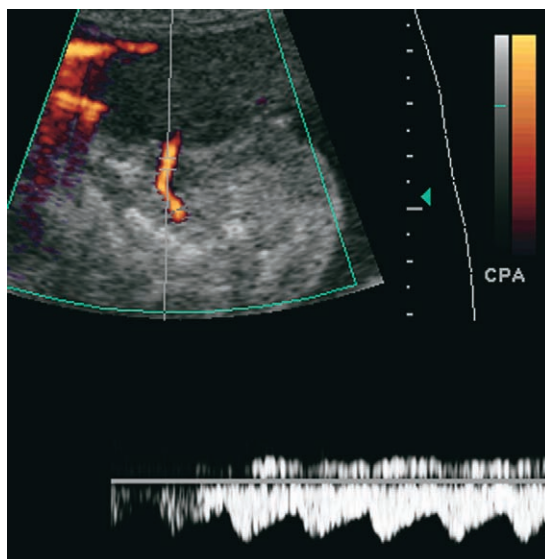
Color and pulse Doppler imaging of an acardiac twin showing pulsatile flow from the donor twin.
